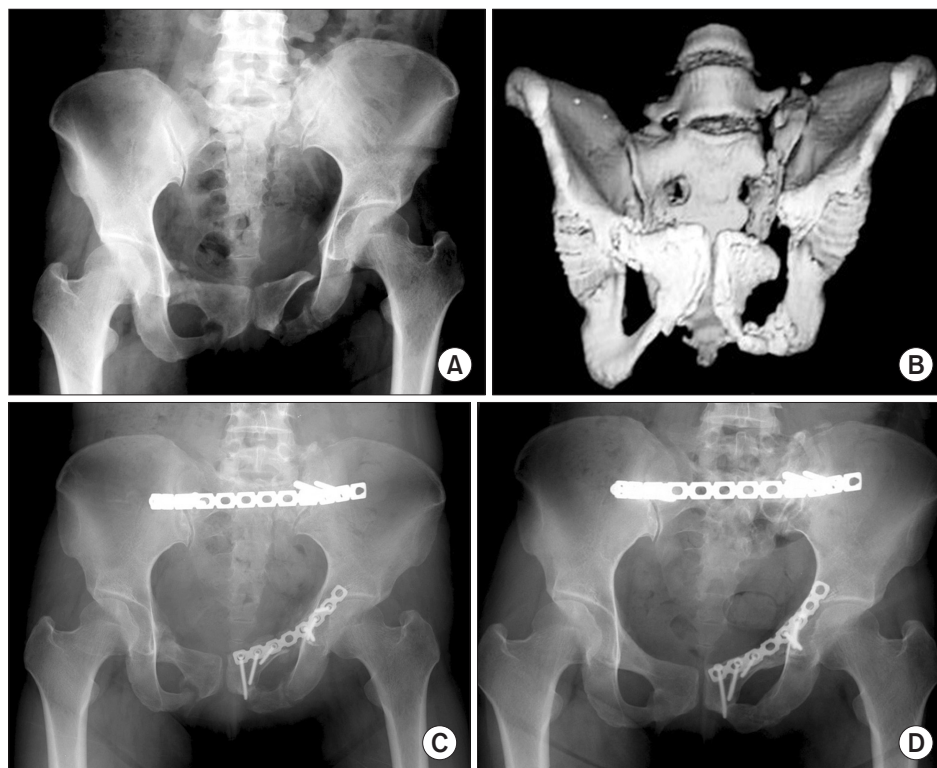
Case 1. (A) Initial anteroposterior view. (B) The three-dimensional computed tomography image shows upward migration and internal rotation deformity of the right hemipelvis. (C) The radiograph obtained immediately after surgery shows correction of the deformity. (D) The radiograph obtained 4 years after surgery shows union and maintenance of the reduction.
